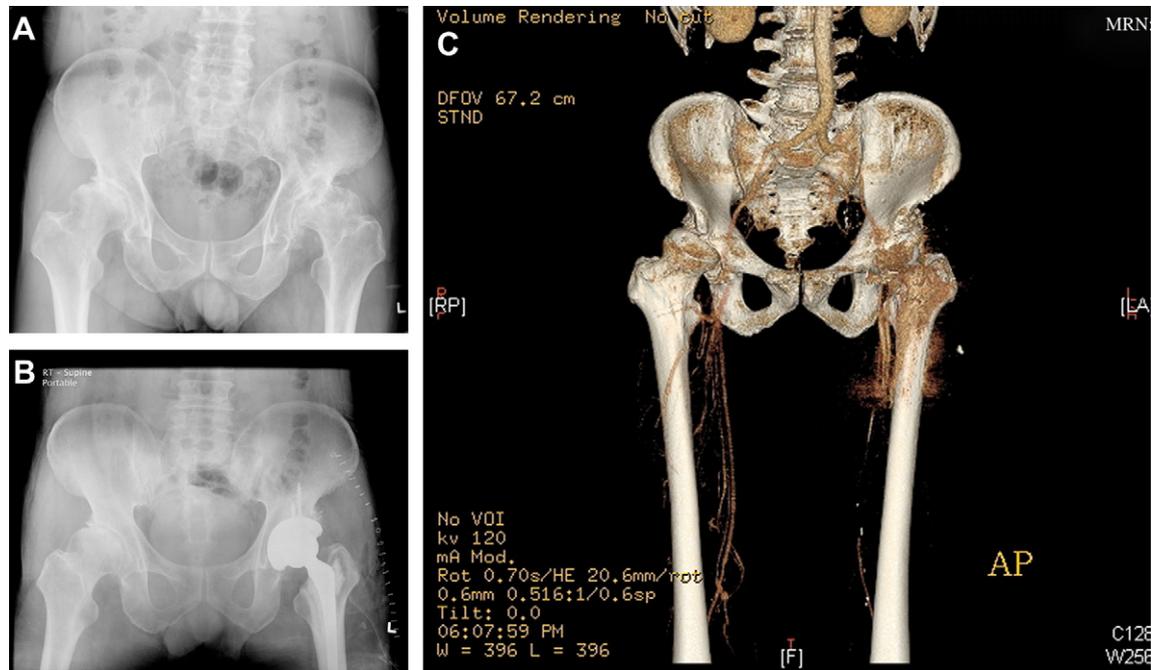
The radiographs show (A) bilateral dysplastic hips with secondary osteoarthritis and (B) the hips after left hybrid total hip arthroplasty was performed. (C) Computed tomography angiogram revealed a long segment of filling defect of the left superficial femoral artery down to the distal thigh level.
